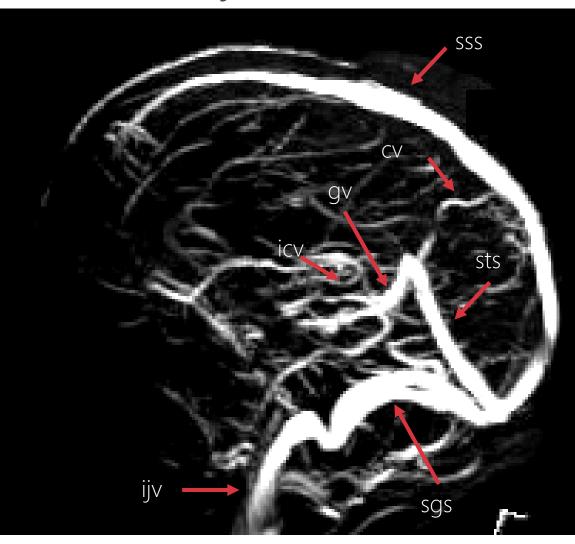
Anatomy of the cerebral venous system as seen on an MRI phlebogryphy.
